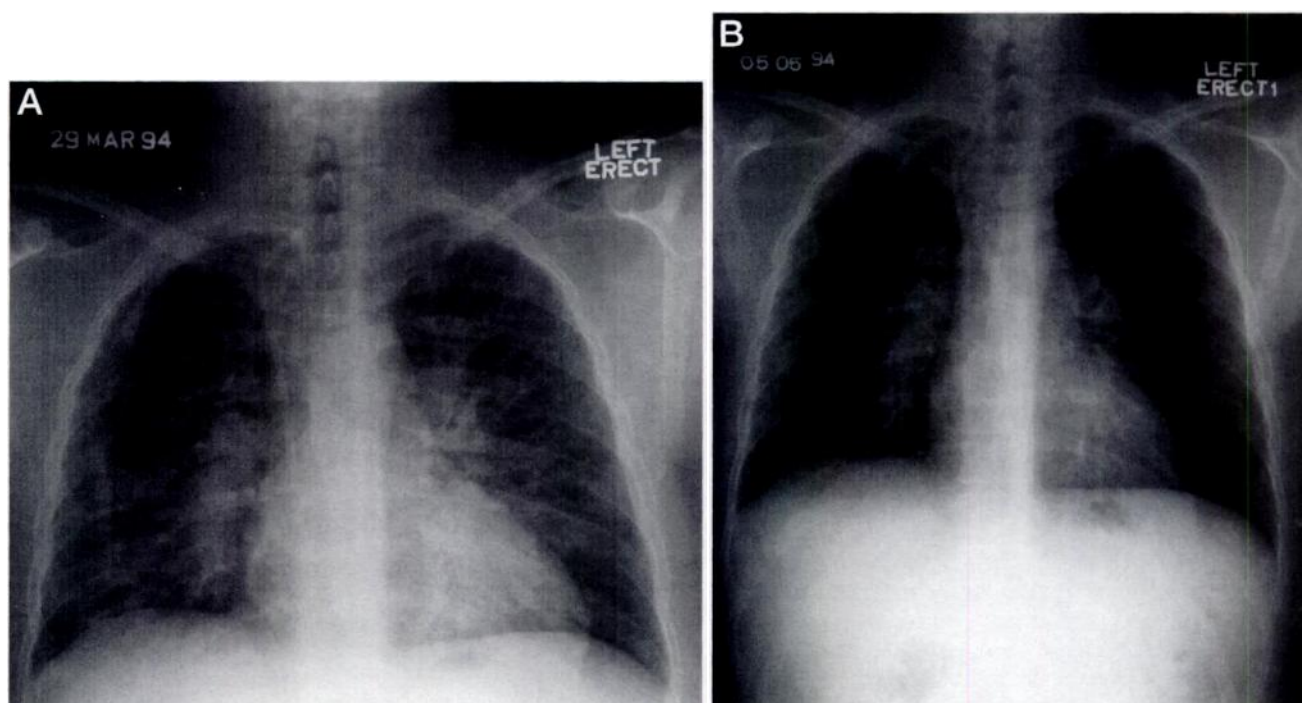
(A) Chest radiograph of Recipient A on presentation with dyspnea showing an interstitial reticulonodular pattern; (B) repeat radiograph 6 wk after transplant nephrectomy and the cessation of immunosuppressive therapy.
